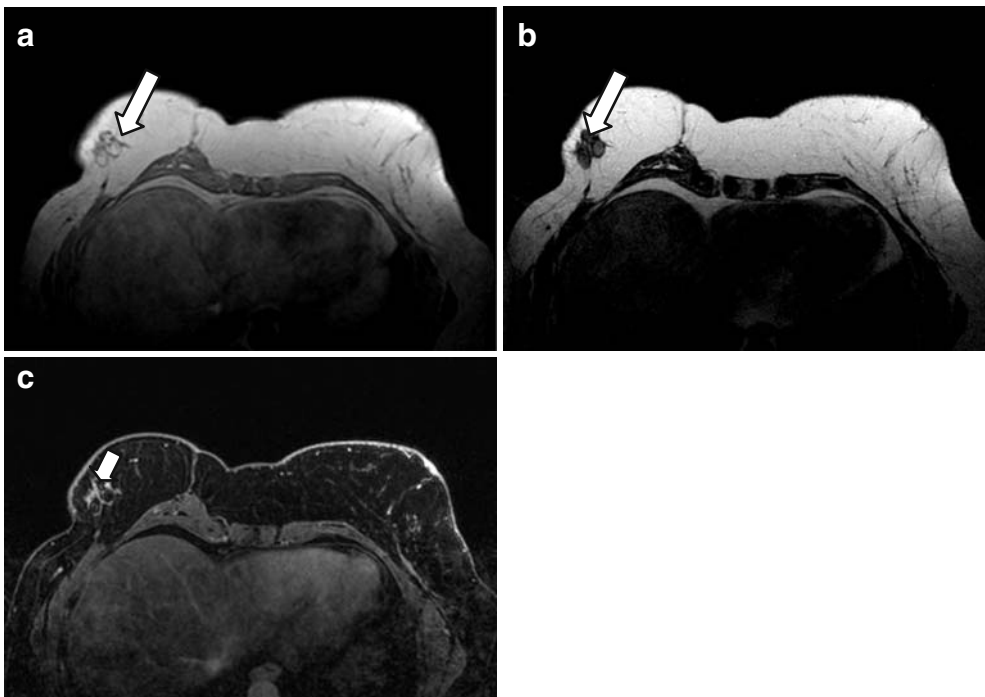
Case number 8901 of April 27th, 2009; 50 year-old patient, right radical mastectomy and breast reconstruction with TRAM flap in 2006; T1 (A), T2-weighted (B) and T1-weighted with fat suppression (C) sequences in the transverse plan showing fat necrosis (white arrows); note the characteristic intensity sign of fat necrosis in C (small white arrow).
